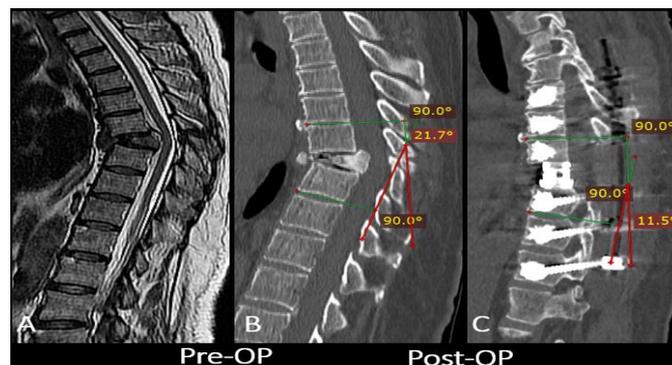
A 59-year-old female patient presented with lower back pain that began three months earlier following heavy lifting, later accompanied by neurological symptoms in the form of lower limb paresis. (A) T2-weighted MRI shows signal loss in the Th8 vertebral body. (B) CT scan reveals kyphotic deformity and collapse of the Th8 superior endplate. (C) Postoperative CT demonstrates posterior decompression, anterior spinal fusion using a V-LIFT cage, transpedicular fixation with vertebroplasty, restoration of sagittal alignment, and decompression of the spinal canal. (Image from the author's personal archive)
